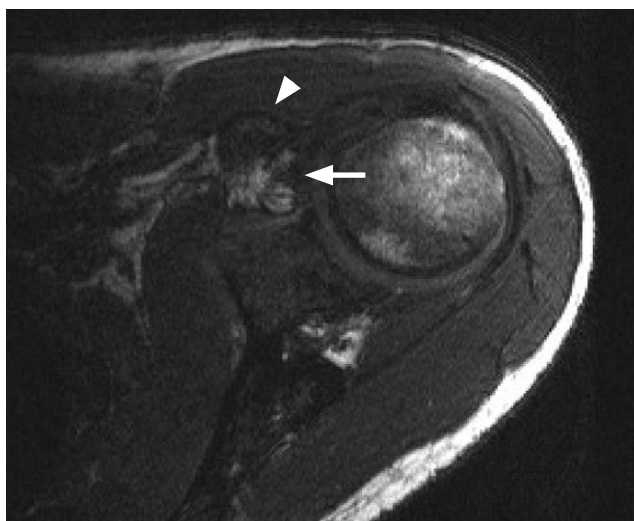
T<sub>2</sub>-weighted magnetic resonance imaging of left coracoid process shows epiphysis with surrounding edema (arrow).
